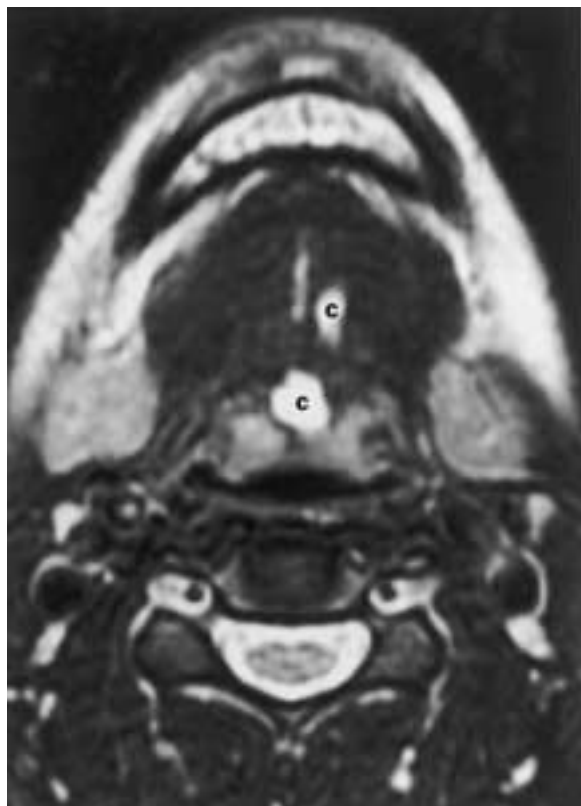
Suprahyoid thyroglossal duct cyst. T2-weighted MR image shows the cyst (C) in the region of the foramen cecum at the base of the tongue.
